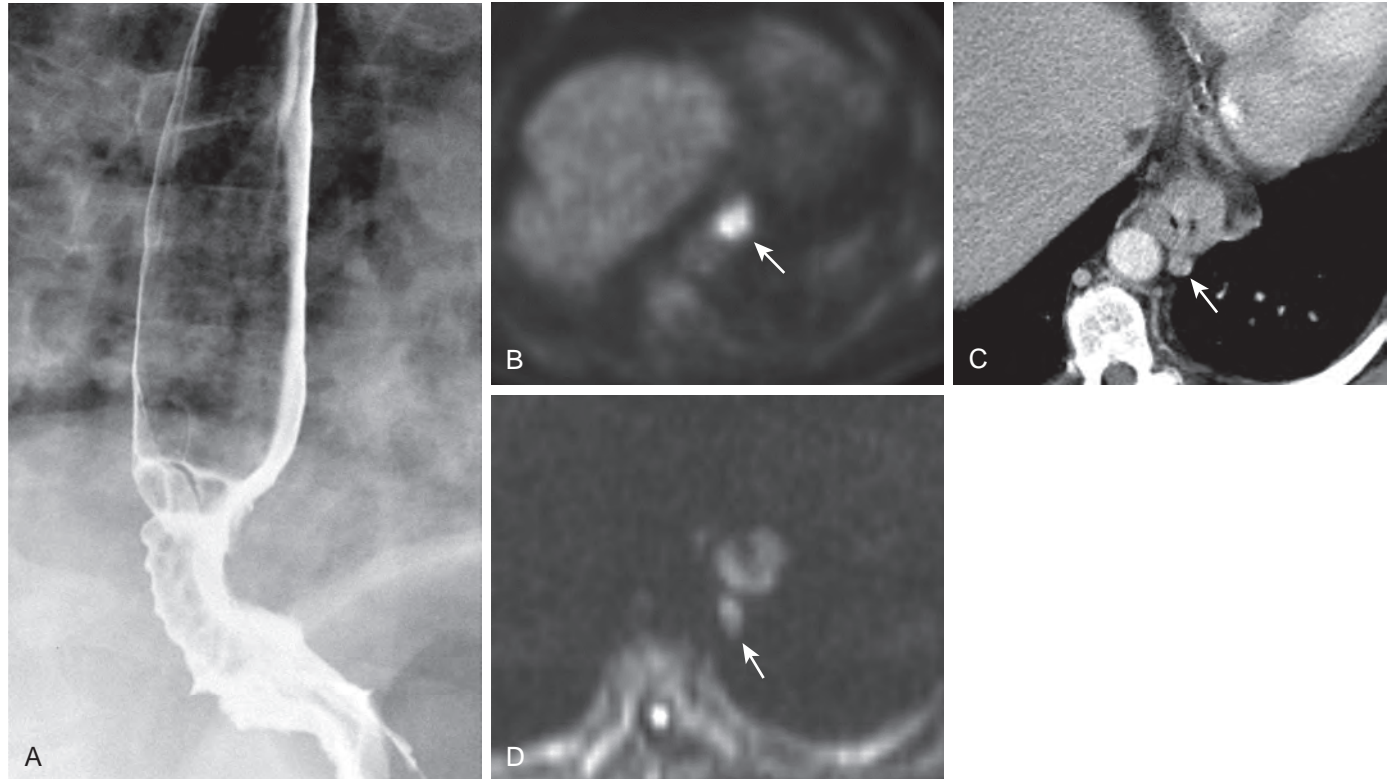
Comparison of MDCT, 18-FDG-PET/CT, and the diffusion-weighted MRI for detecting lymphatic metastasis from esophageal cancer. A. Barium study shows an infiltrating adenocarcinoma of the distal esophagus extending distally into the gastroesophageal junction. B. 18-FDG-PET/CT image shows marked FDG activity (arrow) in the region of the distal esophageal tumor. C. MDCT scan shows an enlarged lymph node (arrow) adjacent to the tumor that was not seen on the PET scan. D. Diffusion-weighted MRI scan shows two areas of increased signal secondary to restricted diffusion on this high B value image. Note how the tumor and adjacent lymph node (arrow) are both clearly visible.
